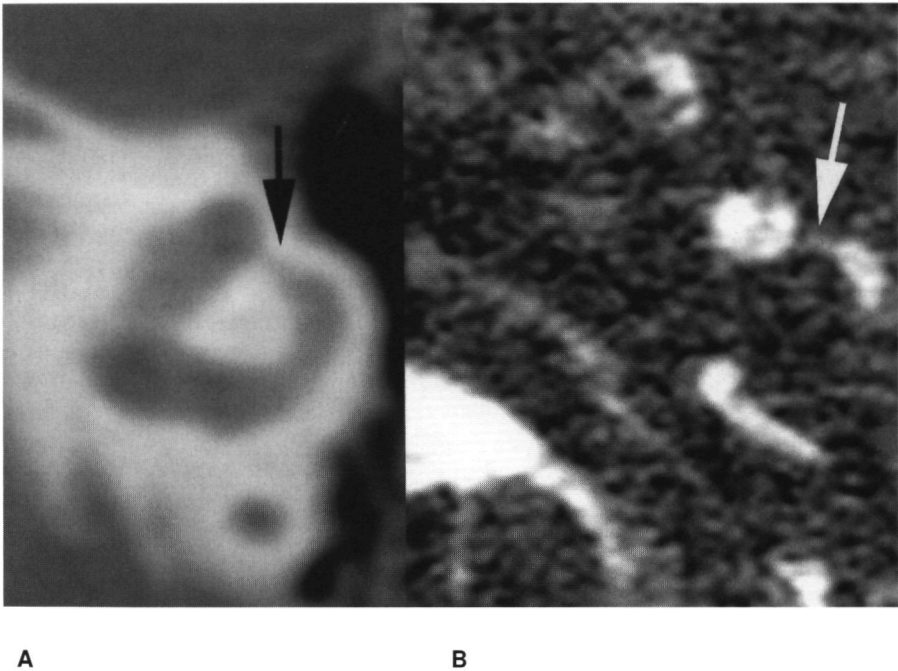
Axial CT image (A) and axial three-dimensional Fourier transformation-constructive interference in steady-state MRI scan (B) through the left lateral semicircular canal obtained from patient IV-1 showing narrowing of the ampulla of the lateral semicircular canal. The ampulla of the lateral semicircular canal, normally the widest part of the canal, is clearly narrowed on both CT scan (black arrow) and MRI study (white arrow). This malformation was found in several members of this family with BOR syndrome.
